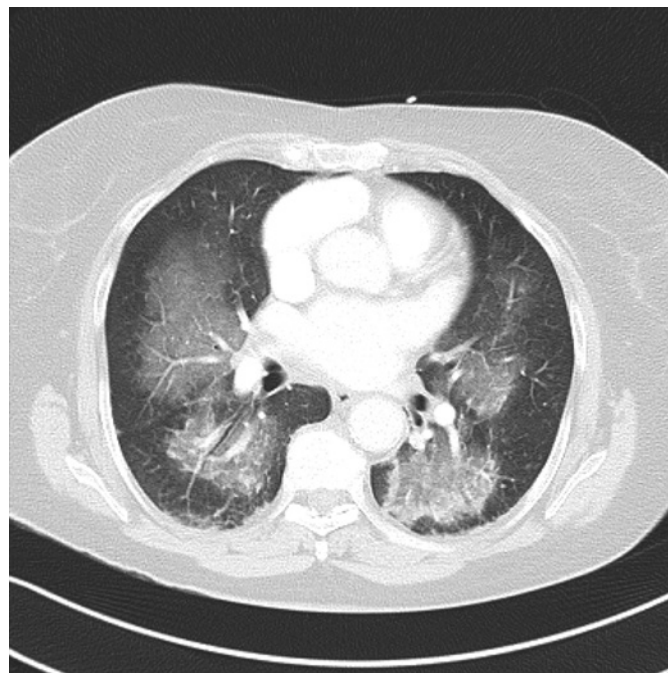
CT angiogram of the thorax after admission.
